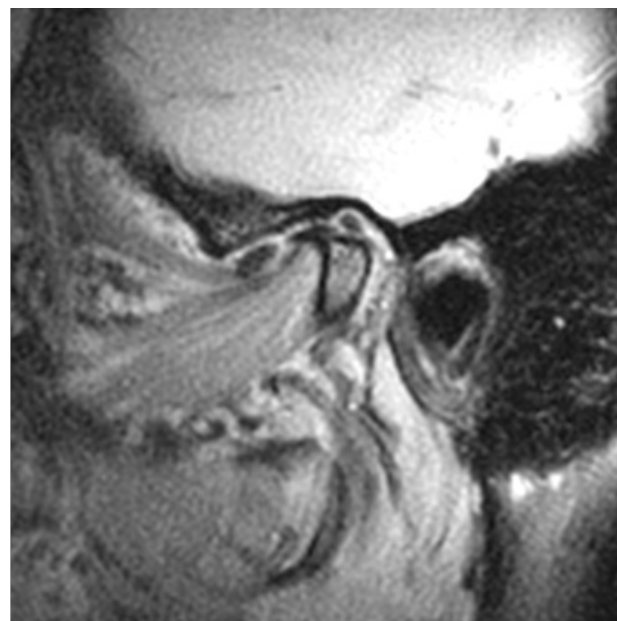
MRI TMJ left closed mouth. Joint head degeneration with disc dislocation.
